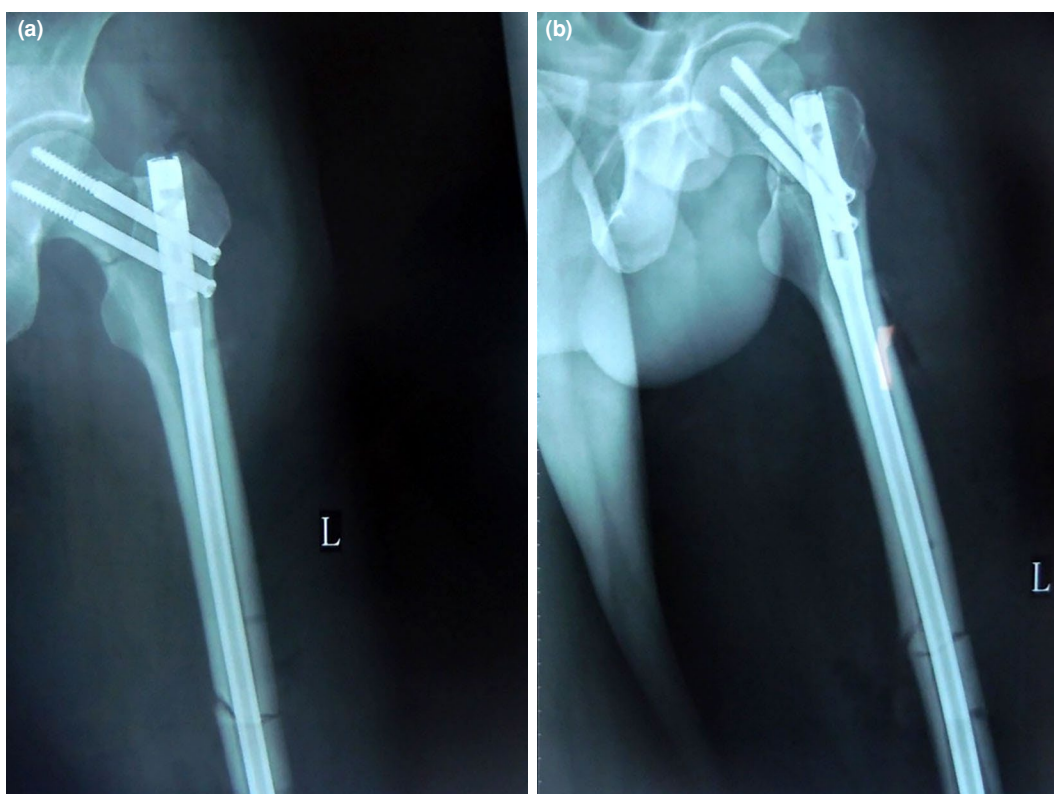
The immediate postoperative X-ray images (anterior and posterior images and lateral images of the femoral neck and shaft) of patients fixed with reconstruction nails assisted by reductor-T tape pin. (a) Anterior and posterior image of fractures fixed with reconstruction nails. (b) Lateral image of fractures fixed with reconstruction nails.
